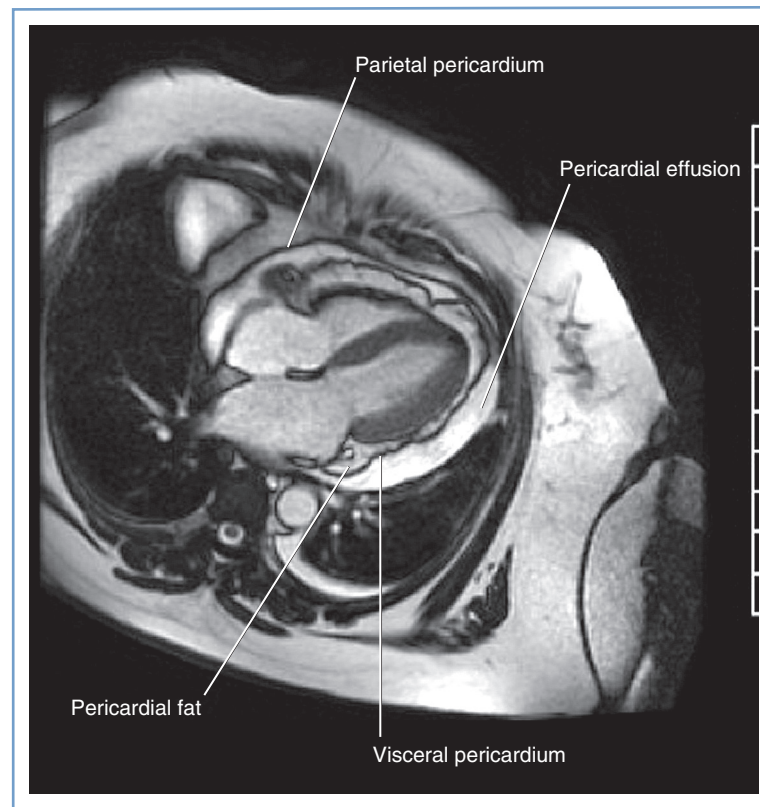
■ Cardiac magnetic resonance image of pericardial effusion. (Courtesy Dr. Afshin Farzaneh-Far, University of Illinois at Chicago, Chicago, IL.)
